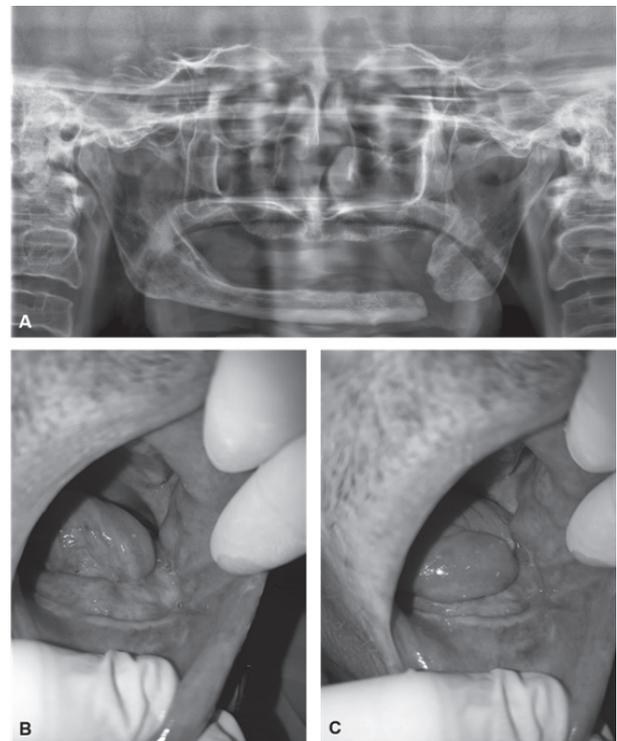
A. Panoramic radiography after seven months of marginal mandibulectomy; B and C. Intraoral photography of the region of the fracture after seven months of the surgery.
